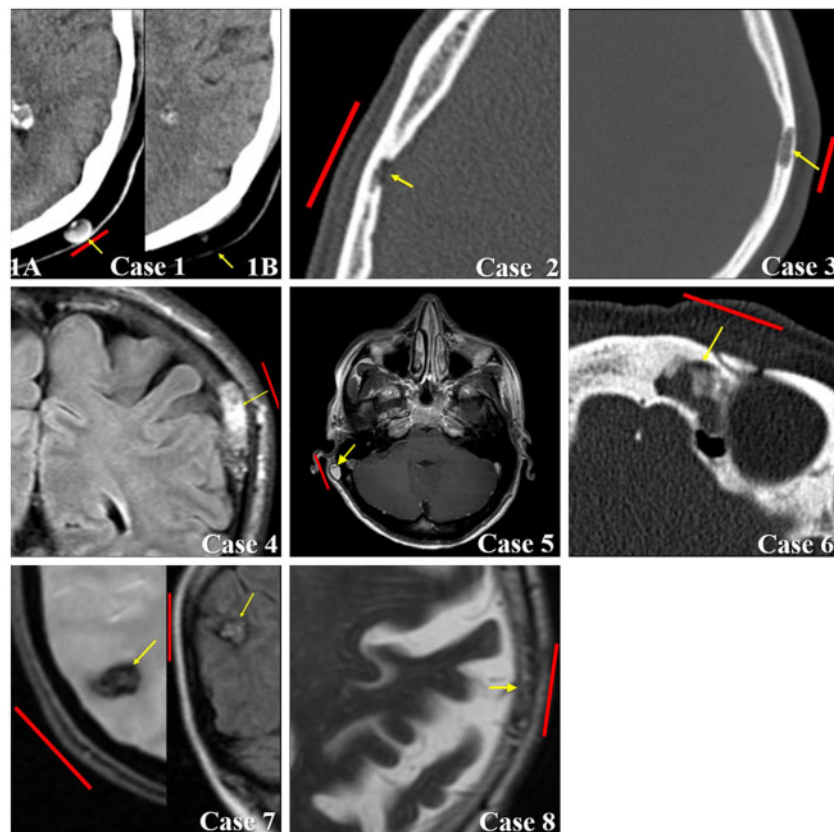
Case 1: (A) Initial cranial CT, where a small subcutaneous mass can be seen in the left occipital region that suggests fibroma, sebaceous cyst, fatty necrosis or pilomatrixoma. Case 1: (B) Follow-up cranial CT 4 years after, where it is observed that the lesion has completely disappeared, only a small scar being visualized in the area of the subcutaneous injury. Case 2. Axial slices of cranial CT in which arachnoid granulation is suggested in right temporoparietal region, also shows an arachnoid cyst in left temporal pole. Case 3. Cranial CT suggested bone hemangioma in left parietal bone as the first possibility. Case 4. Brain MRI showing an intradiploic lesion in left parietal tuber suggesting bone hemangioma. Case 5. Cranial MRI, a bone lesion was observed between the internal and external tables in right occipital, measuring $0.7 \times 0.7 \times 1.5$ cm, suggestive of residual protein or cholesterol cyst. Case 6. Cranial CT showing a suggestive image of left frontal osteoma. Case 7 Brain MRI in axial T2 and coronal T2 flair sections suggesting right parietal subcortical cavernoma. Case 8. Brain MRI in axial T2 showing an alteration in the diploe signal in the left temporal region in a segment of 2 cm, without a clear lytic lesion, suggesting an angiomatous area or initial Paget's disease.
